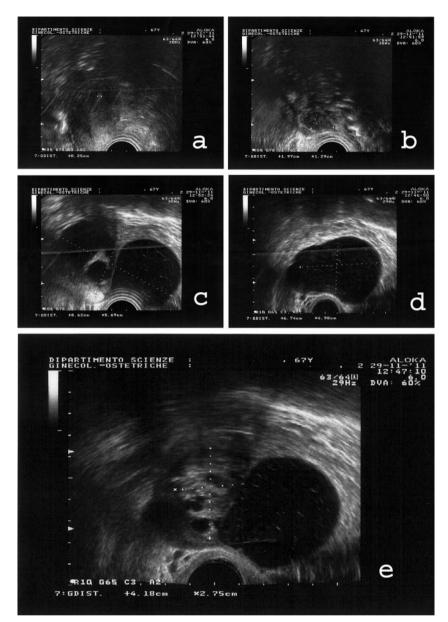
Transvaginal ultrasonographic imaging. a) Left ovary: 19.7 x 12.9 mm. b) Endometrium. c) Right ovary: 86.2 x 56.9 mm. d) Major roundish irregular formation in the right ovary: 67.4 x 49.8 mm. e) Minor formations in the right ovary.
